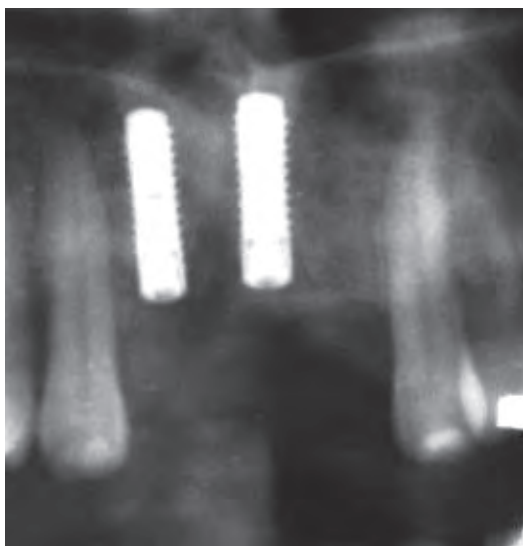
Radiographic verification after implant placement
